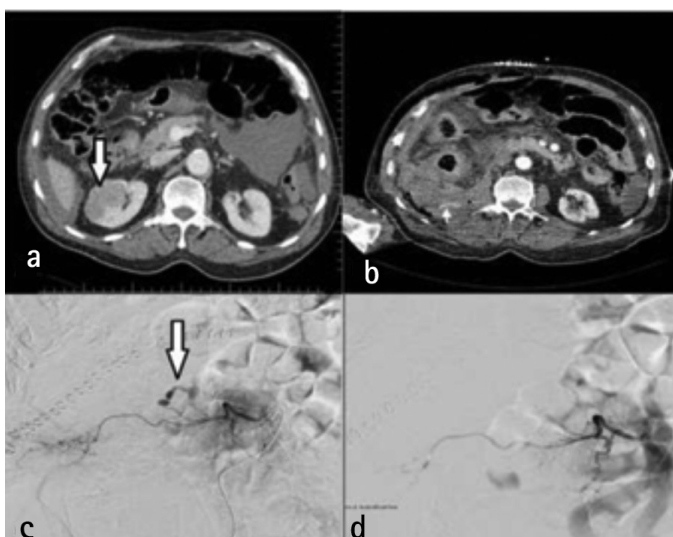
a) Preoperative abdominal computed tomography scan shows the mass (arrow) located at the lateral side of the right kidney. b) Postoperative abdominal computed tomography shows extensive retroperitoneal hematoma and mild contrast extravasation (arrow). c) Pre-embolization angiogram of the right third lumbar artery shows the active bleeding from a dorsal branch of the lumbar artery. d) Angiogram after embolization of the dorsal branch with 15% N-butyl cyanoacrylate and lipiodol mixture shows cessation of extravasation in the dorsal branch of the right third lumbar artery
